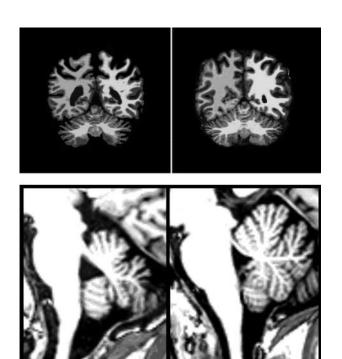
Images obtained from FreeSurfer and MRI (T1), corresponding to an active CS patient (left) and its matched healthy control (right). Reduction in cerebellar volume can be observed in the CS patient.
